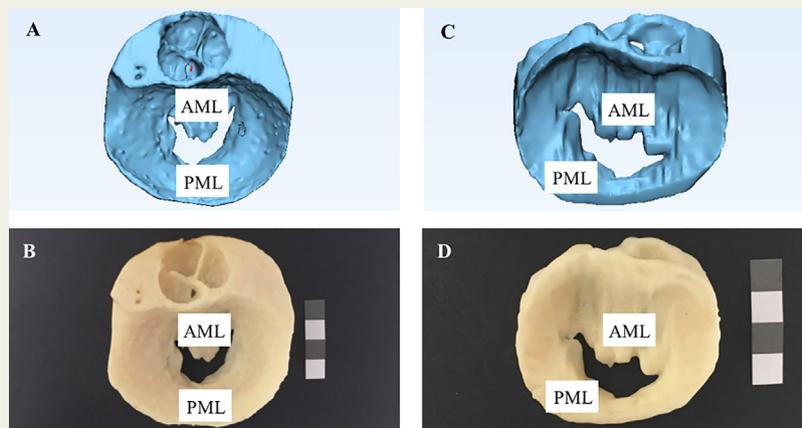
Virtual and 3D printed MV models for patient 3 with functional MV disease. Cardiac CT and 3D echocardiography imaging data was used to produce virtual 3D models (A and C respectively), which were 3D printed using fused deposition modelling (B and D respectively) to compare 3D printed models produced from different imaging modalities. Abbreviations: 3D, three dimensional; MV, mitral valve; AML, anterior mitral leaflet; PML, posterior mitral leaflet. [Note: calibration inset, 10 mm x 10 mm squares].
